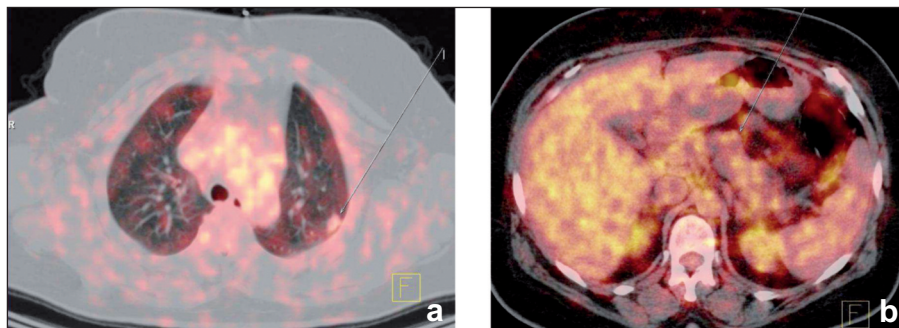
a) Transaxial PET-CT images showed moderate-degree hypermetabolic (maximum standard uptake value (SUV_{max})= 2.6) nodular parenchymal lesion located at left lung upper lobe apicoposterior segment with an approximate size of 1.4x1.0 cm (arrow). b) Transaxial PET-CT images showed a moderate-degree hypermetabolic (SUV_{max}=2.5) pancreatic lesion in diameter of 2.5 cm located at the body of pancreas (arrow).
